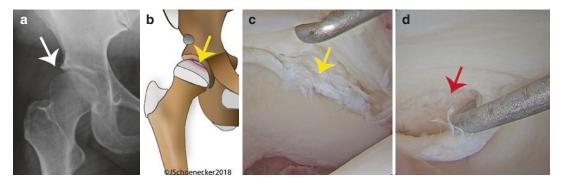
Prevailing theory of osteoarthritis of the hip. Mechanical pathology leads to labral pathology and hip osteoarthritis. (a) Radiographs of a mildly dysplastic hip in 34-year old female with right hip pain (white arrow represents position of patient chondrolabral junction). (b, c)
